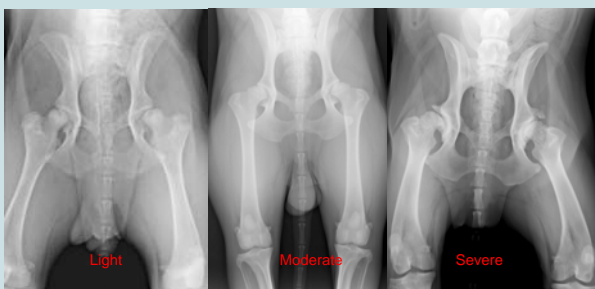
X-rays showing the different stages of the OA score
